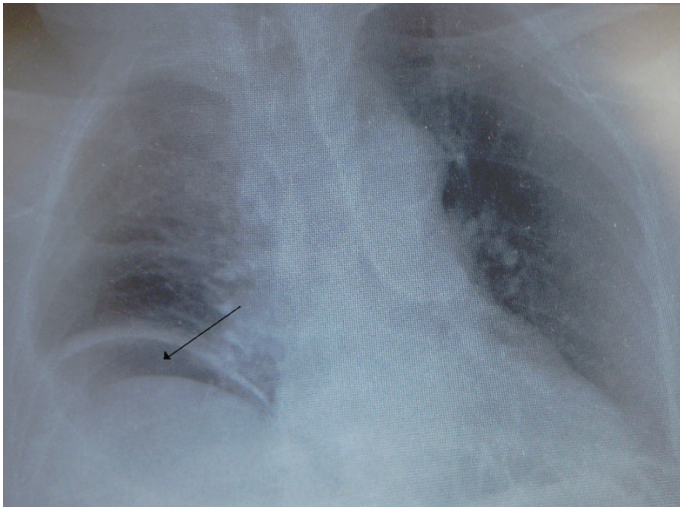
Erect chest radiograph demonstrating free intra-peritoneal air under the right hemi-diaphragm (Heilman 1d)
